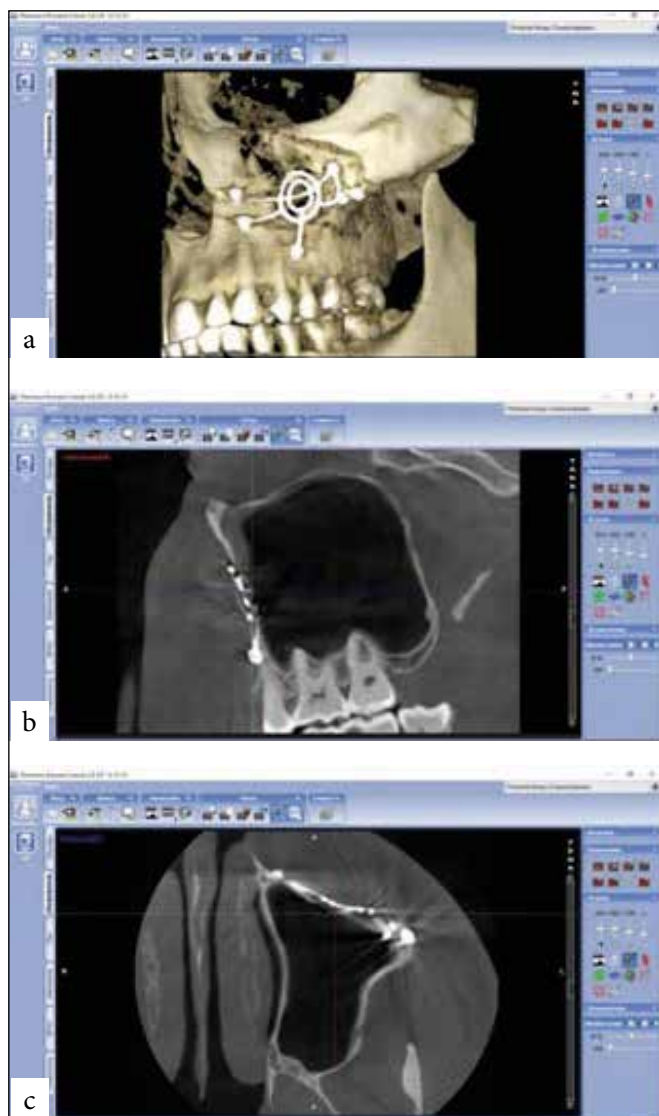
(a,b,c). Control CT patient P., 24 years old, medical history № 4..5789: 6a – 3D reconstruction; 6b – transversal projection; 6c – axial projection.
